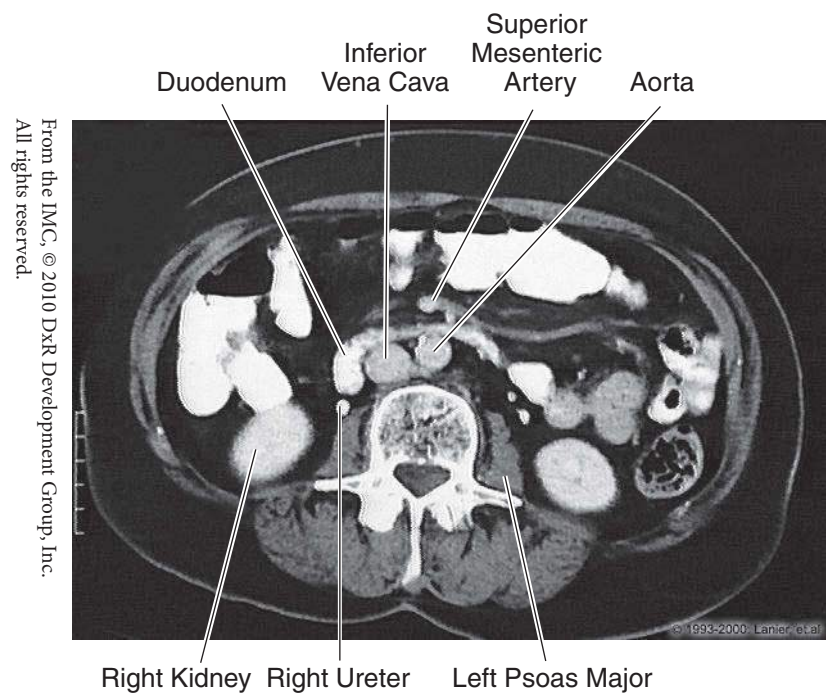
Abdomen: CT, L3
